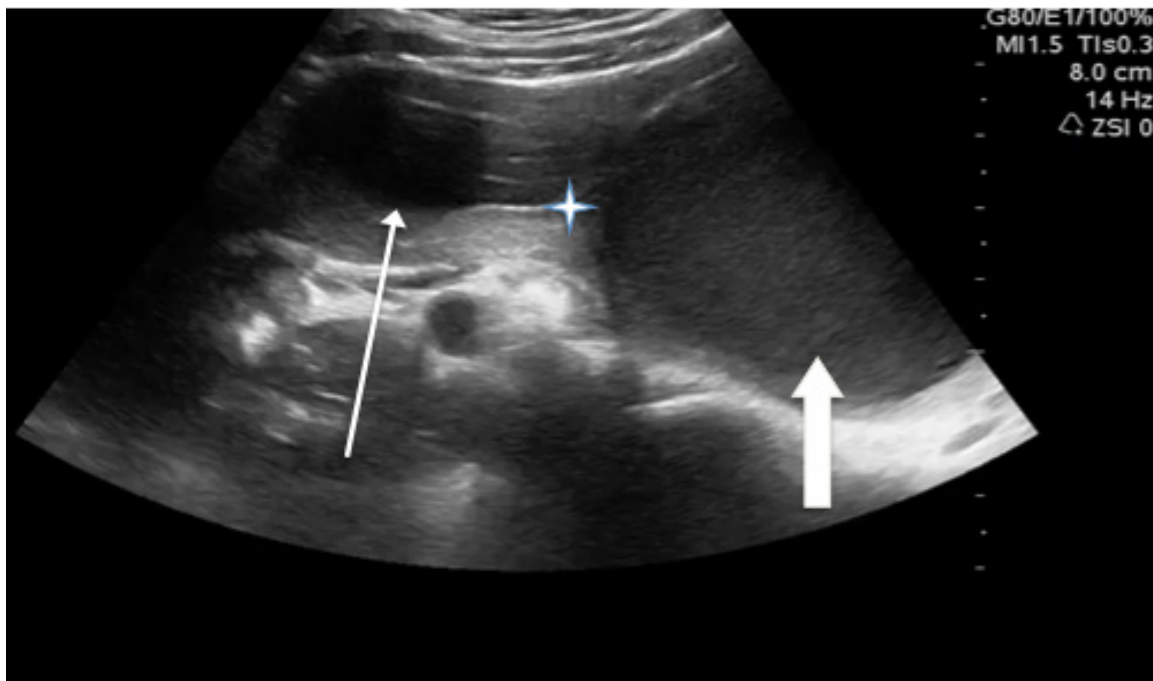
Phased-array, transverse ultrasound scan in the right adnexal region demonstrating a blind hemivagina (thin arrow) and the uterus (thick arrow). Both structures are filled with hypoechoic material and separated by a hyperechoic wall (star).
